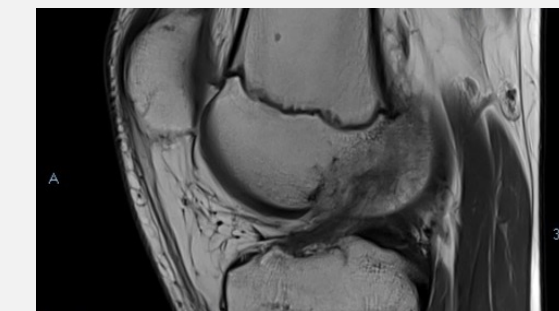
MRI taken 6 months post treatment
